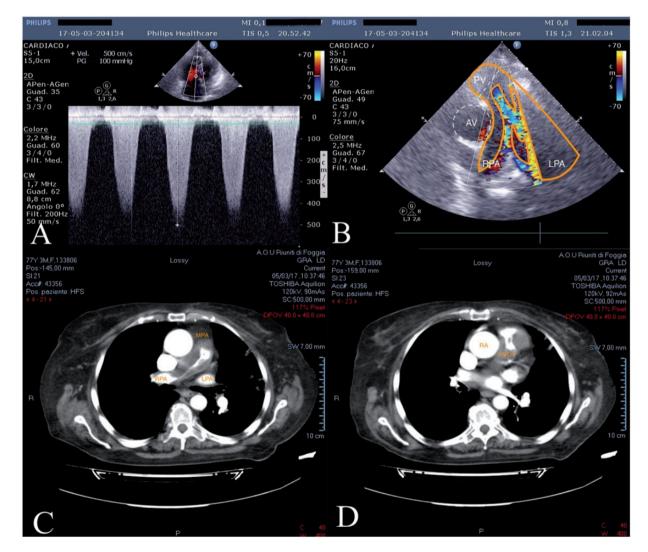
(a) Right ventricle pressure gradient esteemed by tricuspid regurgitation velocity; (b) parasternal short-axis view showing endoluminal hypoechoic mass of the MPA and its branches determining blood flow acceleration; (c, d) chest angio-CT confirming the presence of a nearly occlusive hypodense formation of MPA extending from the RVOT. AV, aortic valve – in dashed circle; MPA, main pulmonary artery; LPA, left pulmonary artery; PV, pulmonary valve – in dashed line; RPA, right pulmonary artery; RVOT, right ventricular outflow tract.
